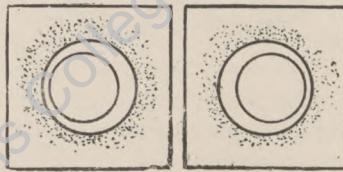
TEST FOR THE SENSE OF PERSPECTIVE.
